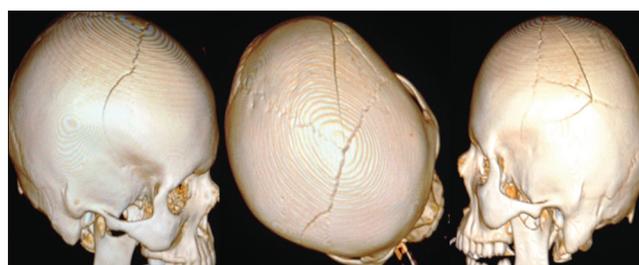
Initial brain computer tomography (CT) of the patient – Reconstruction 3D. Skull fracture reaching the vertex was observed
